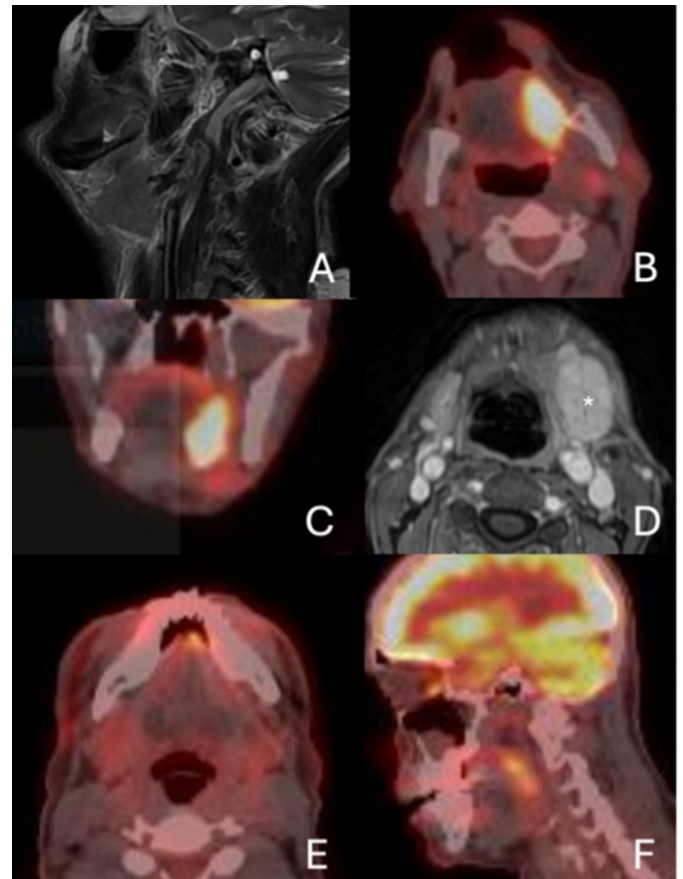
A 70-year-old male diagnosed with squamous cell carcinoma (SCC) of the tongue, characterized by a contrast-enhancing lesion measuring 20x14x35 mm in the left posterior region (A). PET/CT imaging showed a maximum standardized uptake value (SUVmax) of 20.75 within the lesion (B, C). Additionally, enlargement of the left submandibular gland was noted (D). A 53-year-old male diagnosed with SCC of the anterior tongue as the primary lesion. PET/CT imaging revealed mild FDG uptake in 11 mm lymph nodes in the left submandibular and upper jugular regions, indicative of metastasis (E, F).
